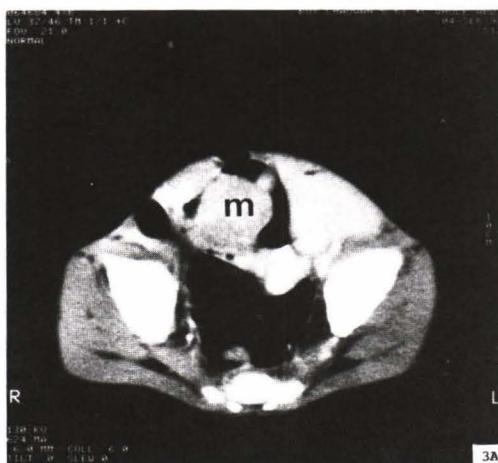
(A, B) CT scans of abdomen shows the same findings.
